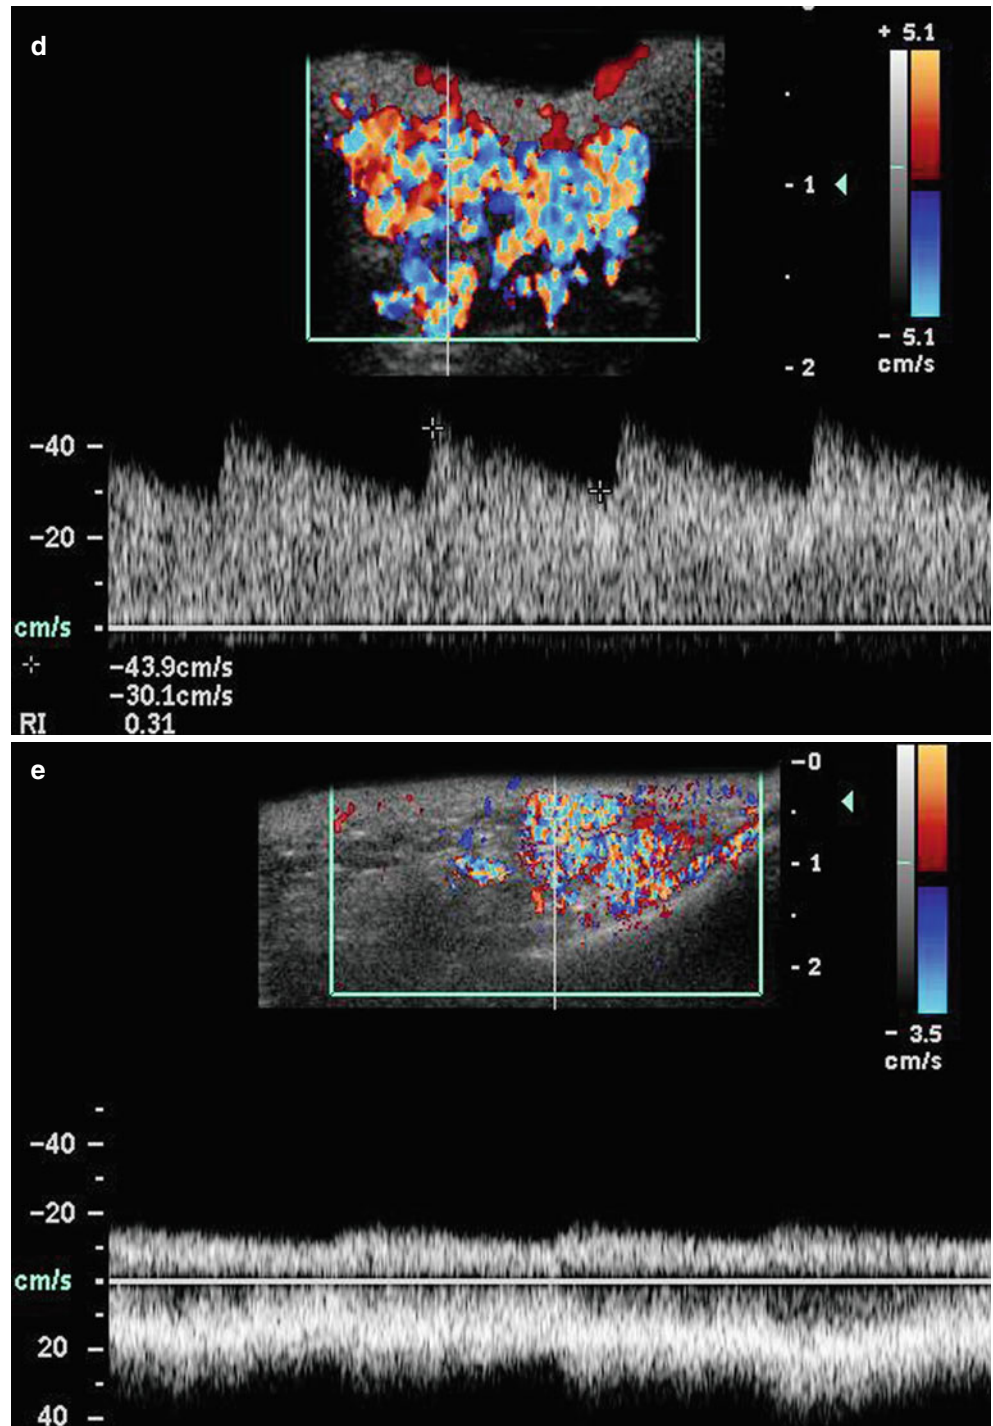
(a, b) High-flow arteriovenous vascular malformation. (a) Grey scale ultrasound image of a small subcutaneous lesion consisting mainly of tortuous venous components (*arrows*). (b) At the lower pole of the lesion however a small arterial feeder is demonstrated, corresponding with a high-flow arteriovenous malformation
